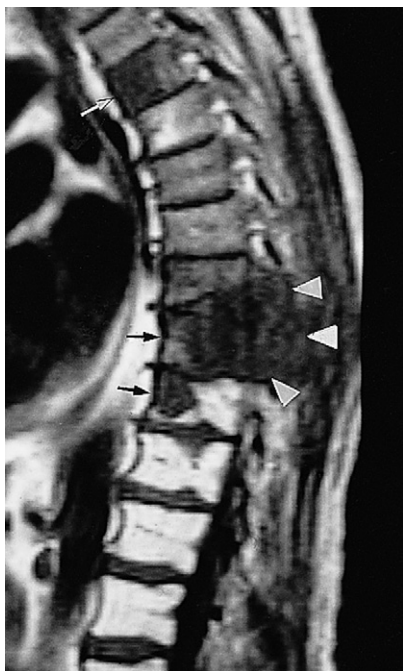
Metastases from carcinoma of the prostate. Sagittal whole spine MRI scan showing low signal intensity in several vertebral bodies (arrows). Note the metastases also involve the posterior elements of two adjacent vertebrae (arrowheads).
